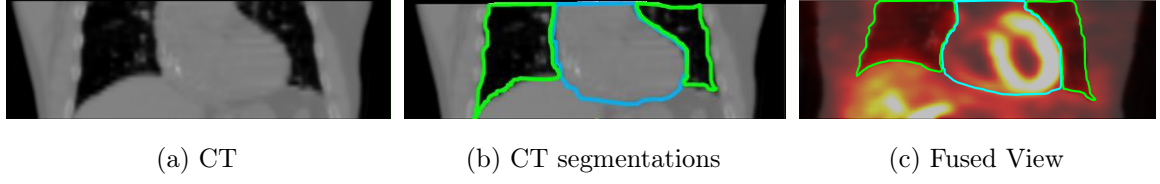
Visualization of the cardiac alignment metric computation. A cardiac CT volume (a) is segmented into lung and mediastinum region (b) and then fused with a SPECT volume (c). The ratio of how much SPECT uptake resides inside the lungs versus inside the mediastinum suggests how well the two volumes are aligned.
